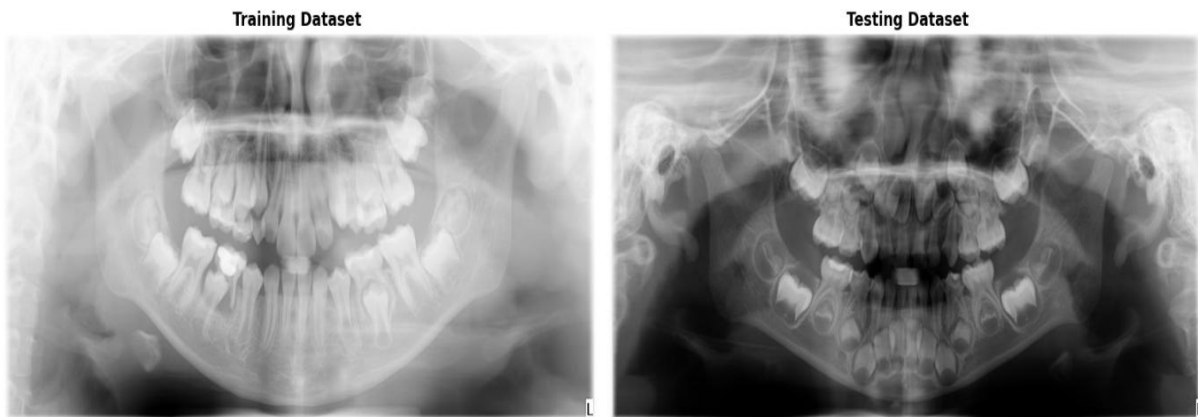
Representative Pediatric Panoramic Radiographs from the Training and Testing Datasets
